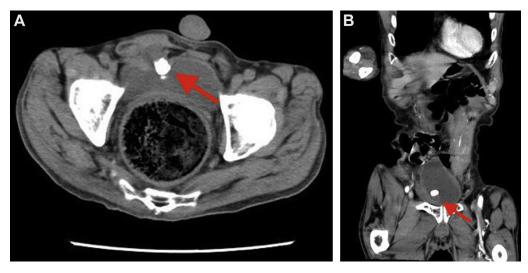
(A) axial and (B) coronal section of CT. Contrast-enhanced CT showing a thick stone adhered to the anterior bladder wall (arrow).
